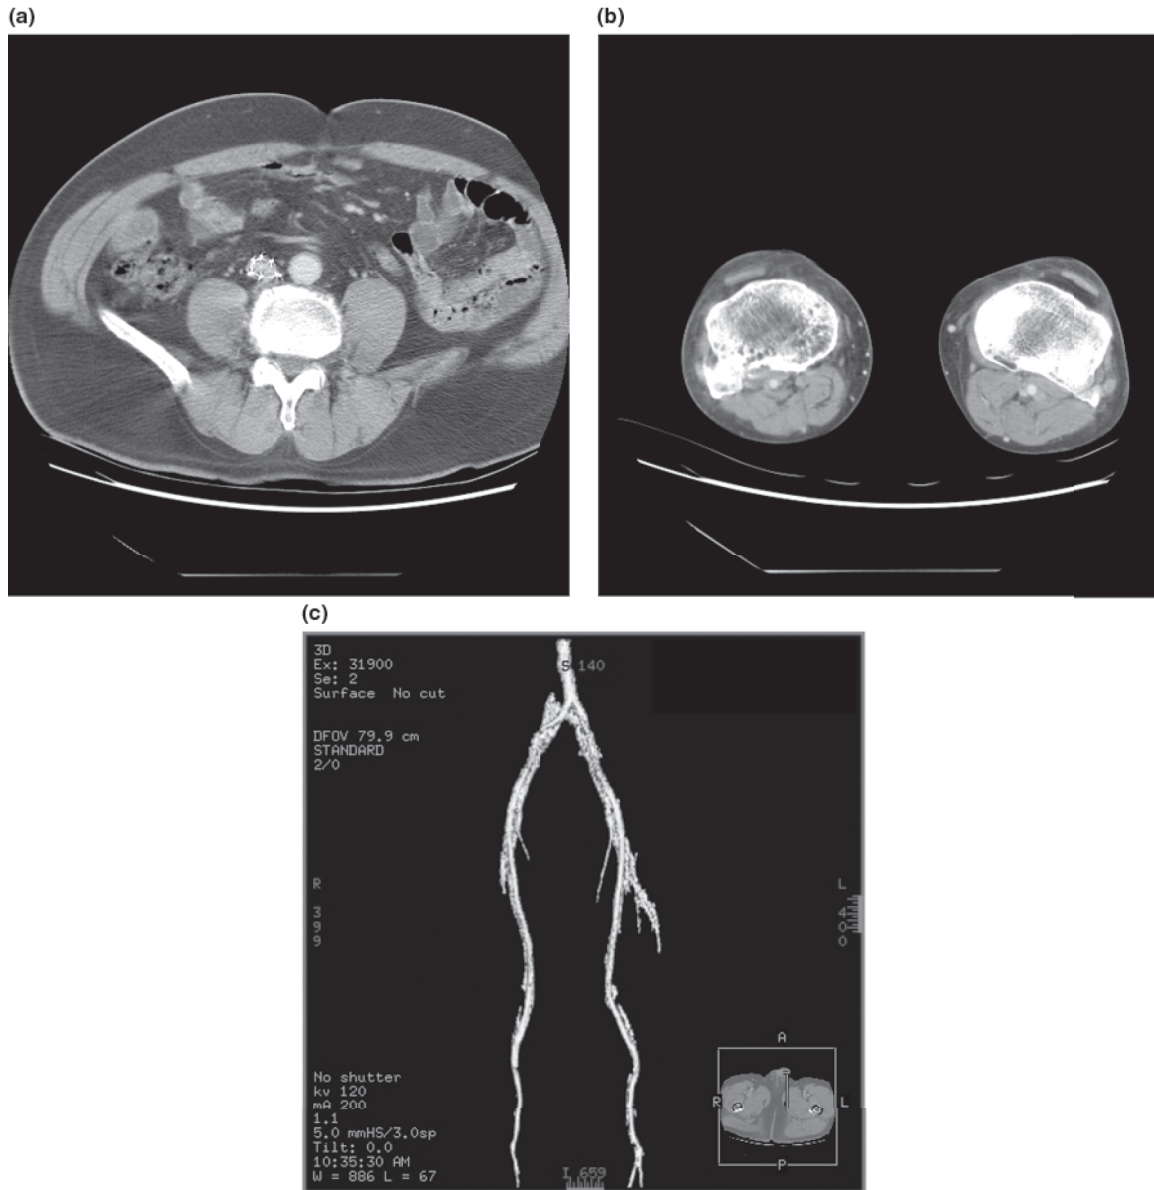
Follow-up lower extremity computed tomographic angiogram shows the evidence of inferior vena cava filter placement (a) and normal venous system in both lower extremities (b, c).
